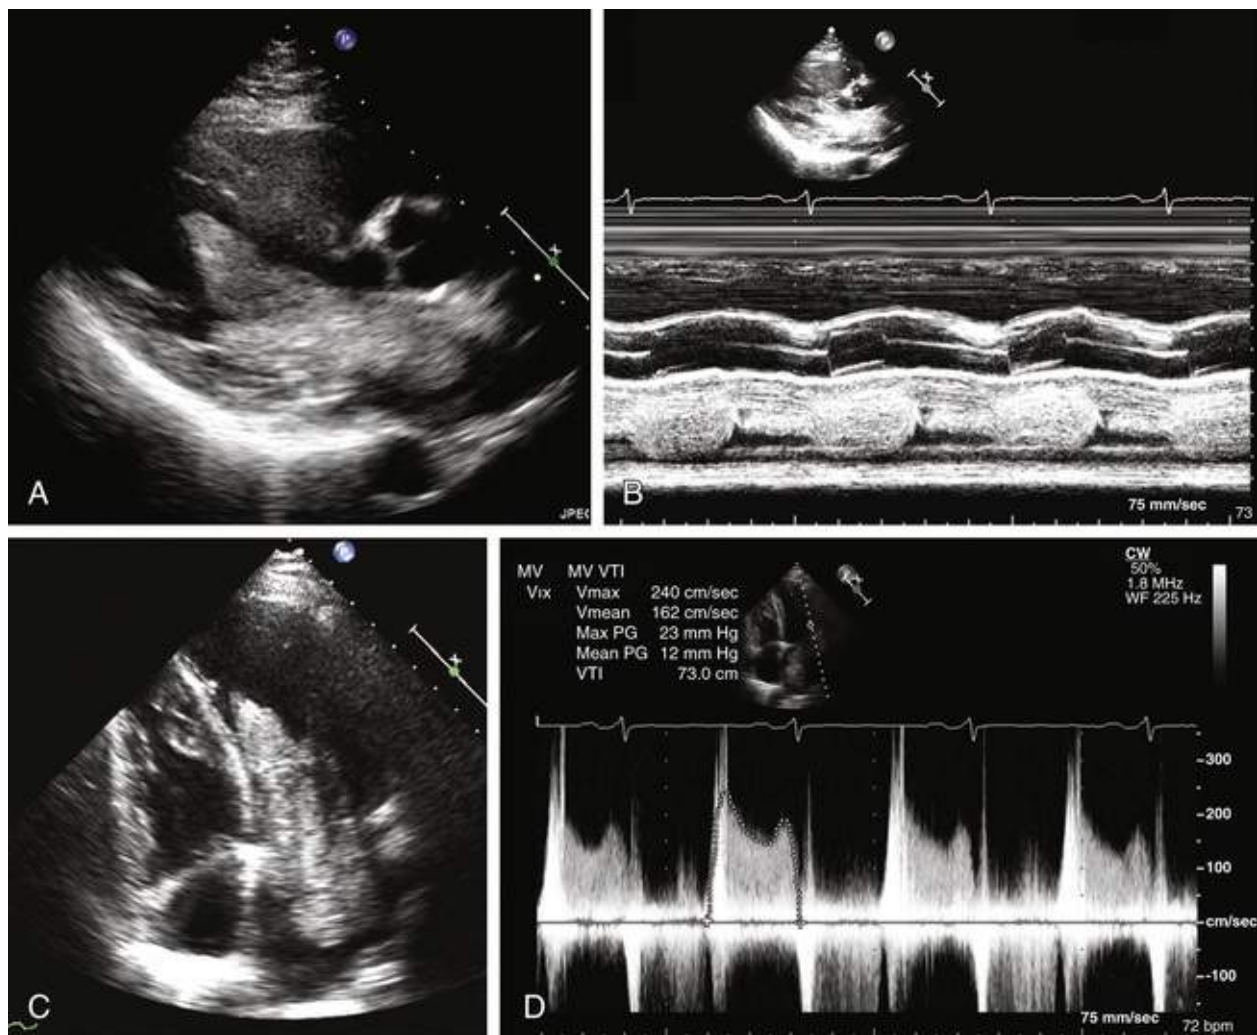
Left atrial myxoma. A, Parasternal long-axis view. B, M-mode view showing the mass prolapsing through the mitral valve into the left ventricle in diastole. C, Apical 4-chamber view. D, Transmittal gradients (mitral stenosis) as shown by CW Doppler, with peak and mean gradients of 23 and 12 mm Hg. (Modified from Wu J. Cardiac tumors and masses. In Stergiopoulos K, Brown DL, editors. Evidence-Based Cardiology Consult. New York: Springer Science + Business Media; 2014.)
